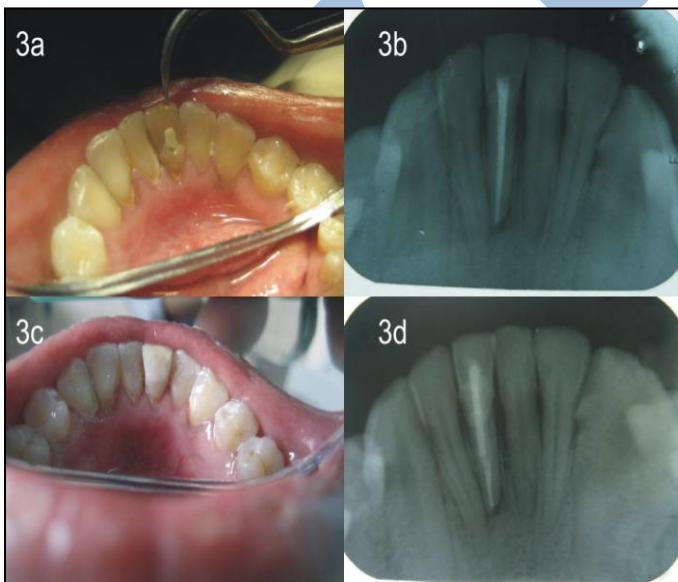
Clinical view of fractured mandibular left central incisor.3b.Radiograph showing fracture line and tooth was root canal treated.3c.Clinical view after completion of treatment.3d.Radiograph after sealing the crown fragment.
